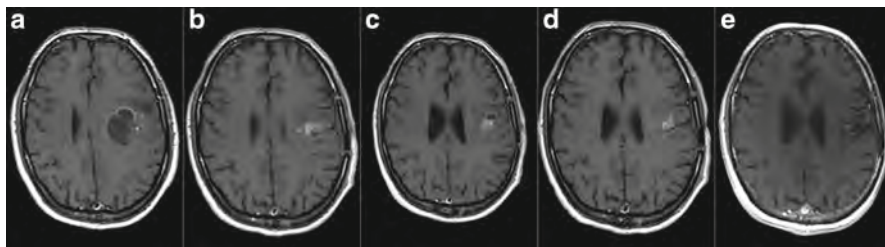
T1-weighted post-contrast MR images of a 41-year-old man with GBM which recurred following partial surgical resection and radiotherapy with concomitant daily temozolomide. (a) Before initial surgery, GBM was detected on MRI in the left frontal region. (b) Seven months after initial diagnosis, an enhancing lesion suspected to be recurrent or residual tumor was detected and treatment with the Optune® device was initiated. (c) Seven months after initiation of TTFields, the enhancing lesion became partly cystic. (d) Ten months after initiation of TTFields, regression of the cystic portion of the lesion was detected, but a subtle enhancement was still present. (e) The faintly enhancing region remains without progression 94 months after initiation of TTFields. *GBM* glioblastoma multiforme, *MR* magnetic resonance, *TTFields* Tumor Treating Fields. Rulseh et al. Long-term survival of patients suffering from glioblastoma multiforme treated with tumor-treating fields. *World J Surg Oncol*. 10:220, 2012. BioMed Central
